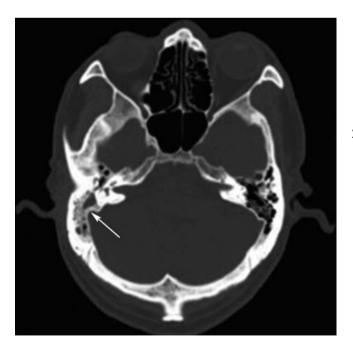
Bilateral mastoid plain CT scan (bone fenestra). Wellgasified left nidus Vespa, right mastoid nidus Vespa filled with slightly high-density fluid (arrow)
